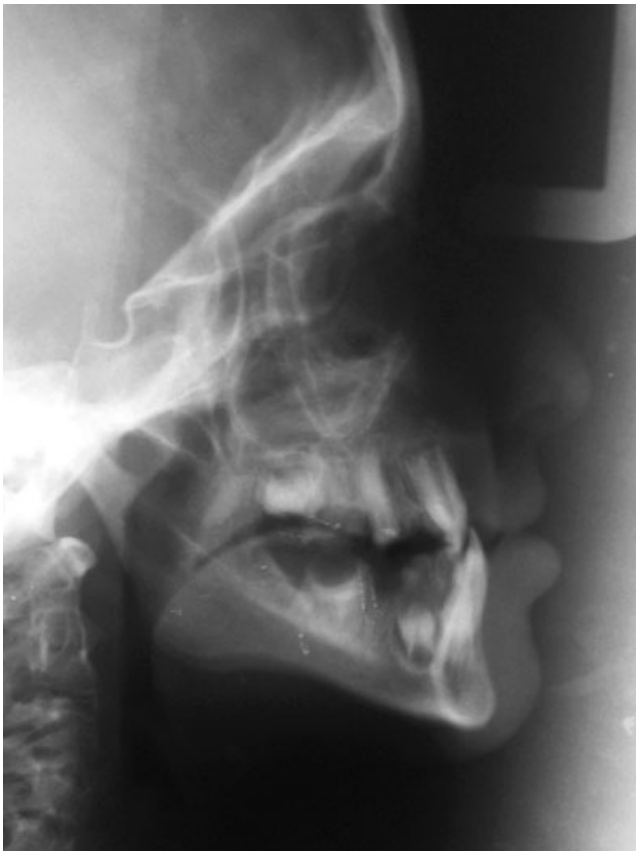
Lateral skull radiograph
